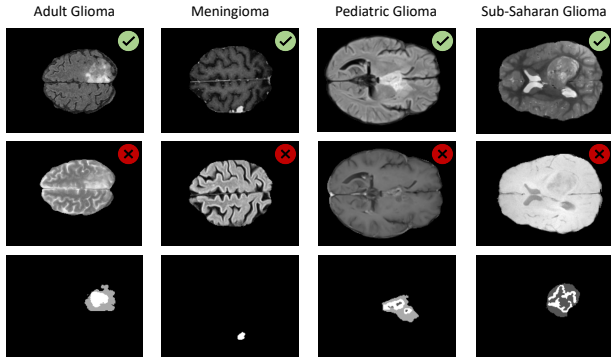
Different brain tumor images. Visual examples of patients where one MRI modality contains information to effectively segment the complete tumor contour and another does not.
